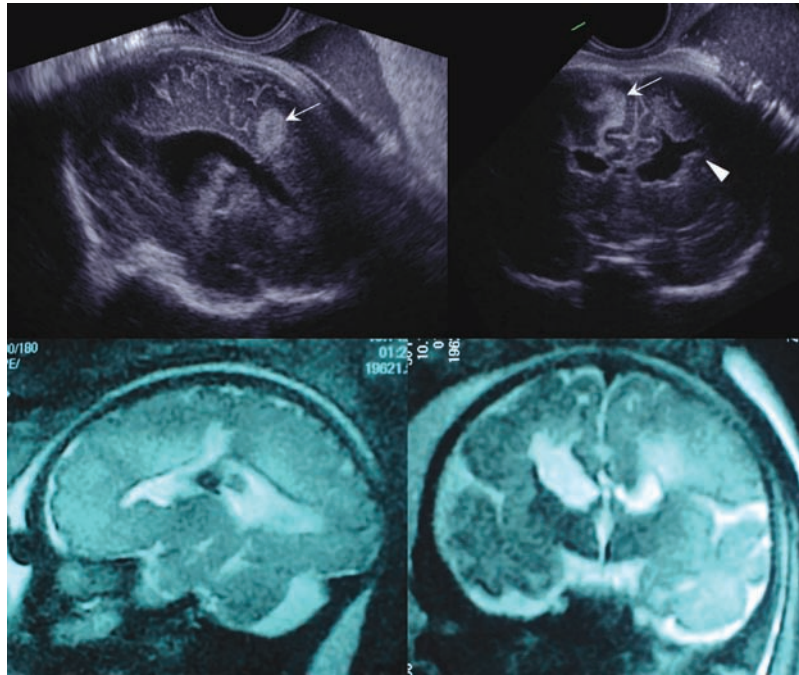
Ultrasound and MR images in a fetus with cerebral hemorrhage and mild ventriculomegaly at 35 weeks of gestation. Ultrasound parasagittal (upper left) and anterior coronal (upper right) images of the brain. Arrows indicate intracerebral hemorrhage. Arrowhead shows a porencephalic part fused with the lateral ventricle. Lower figures are MR images showing the same cutting sections as upper ultrasound images.
